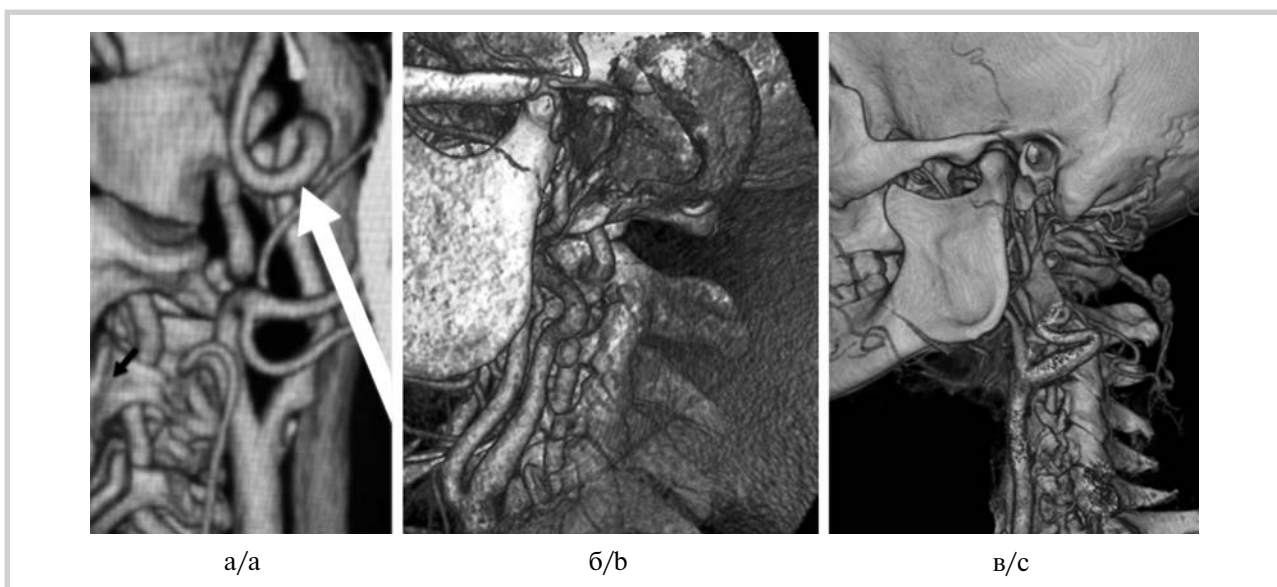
3D-CT angiography of the brain.
